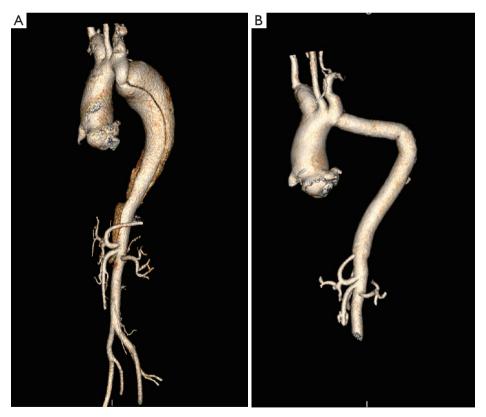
Pre- and post-operative imaging of patient No. 1. (A) Preoperative CTA demonstrating that the range of dissection extends to the renal artery; (B) postoperative CTA demonstrating complete elimination of constricted segment and dissection. CTA, computed tomography angiography.
